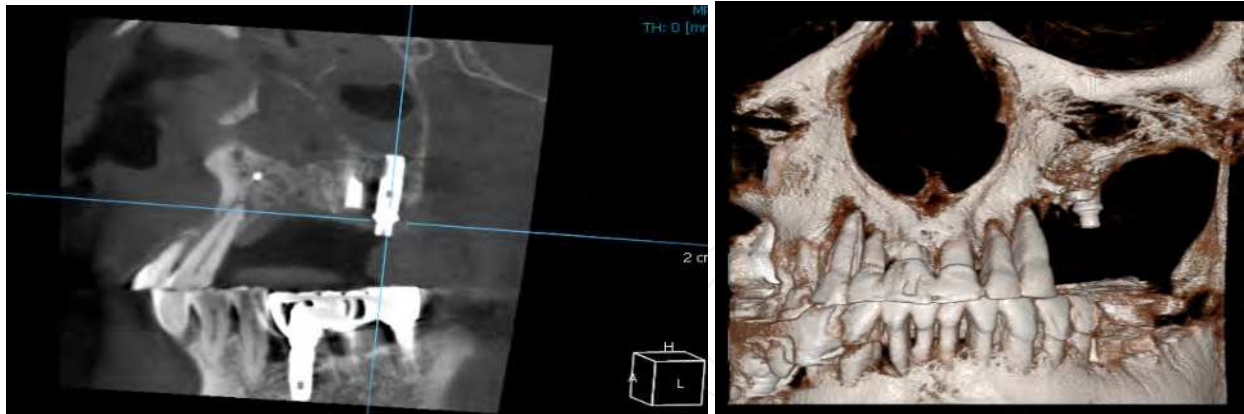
Accurate 3 dimensional image data of Cone Beam CT (AZ-3000 CT, ASAHI)
